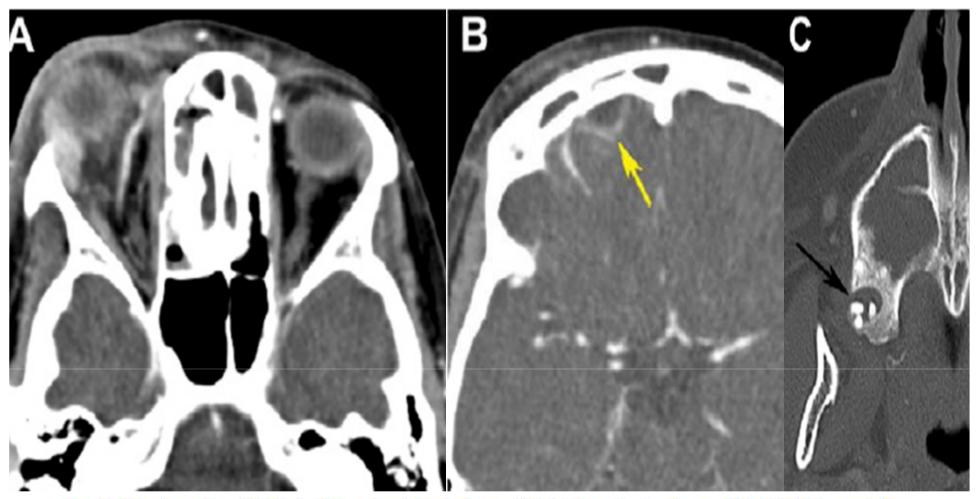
Odontogenic orbital infection and epidural abscess. (A) Axial contrast-enhanced CT (CECT) through the right orbit demonstrates orbital cellulitis and phlegmon. (B) Axial CECT demonstrates an epidural abscess of the right frontal lobe (arrow). (C) Axial CECT demonstrates periapical lucency in a right maxillary molar, which was the source of infection in this patient (arrow). This patient also had odontogenic sinusitis of the maxillary sinus.
